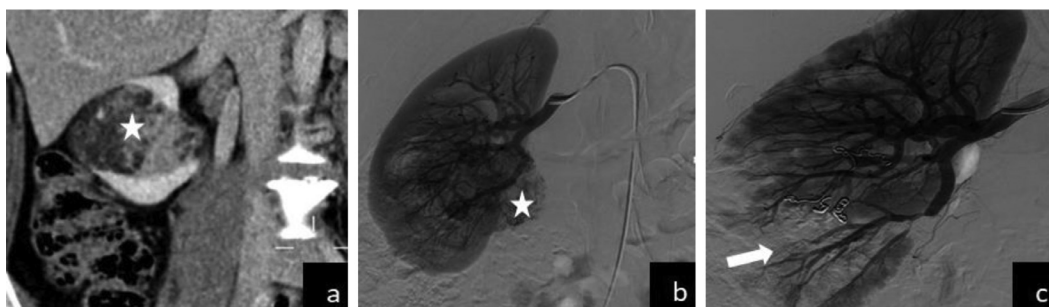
A: CT with frontal reconstruction: right renal angiomyolipoma (star) including fat tissue. B: Renal arteriography: opacification of the renal parenchyma and of the angiomyolipoma (star). c: Renal arteriography showing devascularization of angiomyolipoma (arrow)
